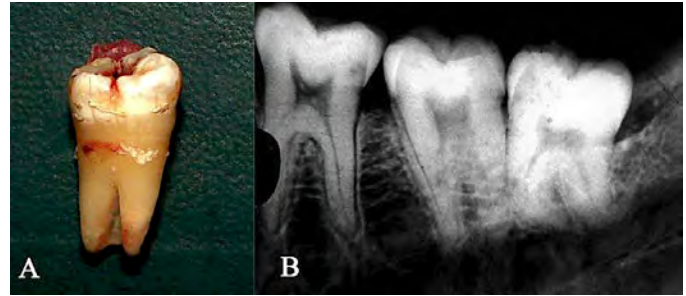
(Left) Extracted mandibular left second molar having a C-shaped root. (Right) Radiograph of the mandibular right second molar having two separate roots. Case is a 37 year old male.
